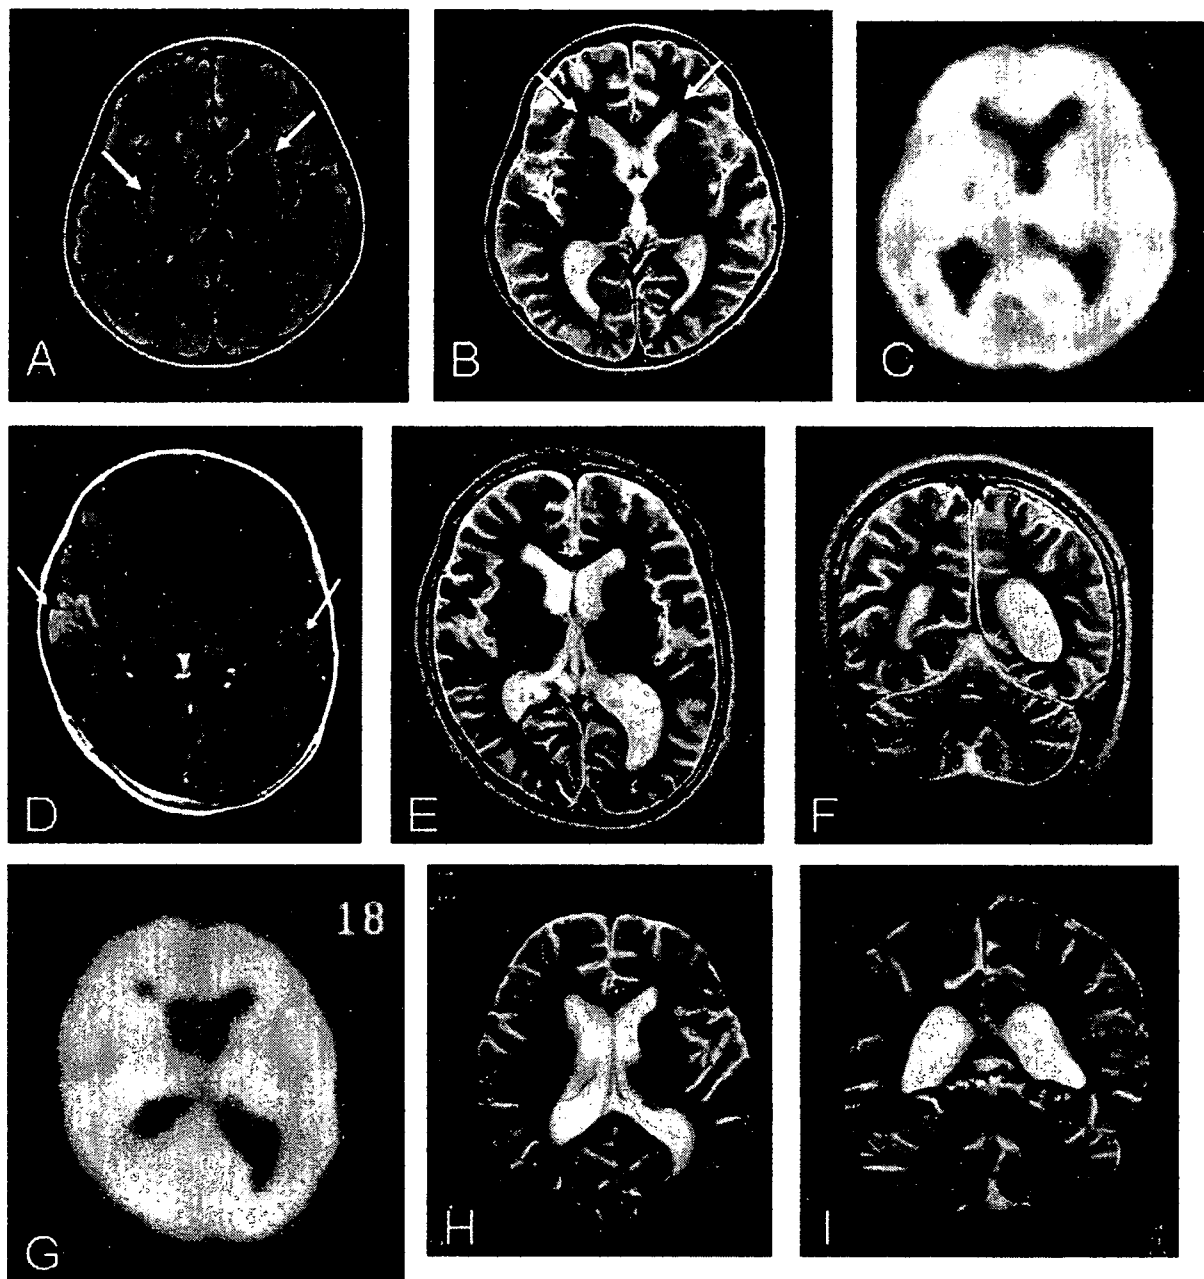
Neuroradiological findings of patients with AERRPS (A–C, patient 1; D–G, patient 2; H and I, patient 3). (A) Fluid-attenuation inversion recovery (FLAIR) image showed high signal intensity in bilateral caudate (arrows). (B) Diffuse cortical atrophy appeared during the recovery phase, in association with a high-intensity lesion at the periventricular white matter (arrows) on T2-weighted MR image (T2WI). (C) SPECT study revealed a slight decrease of blood flow at the bilateral frontal cortex. (D) Enhancement of bilateral temporal cortex is observed. (E and F) Diffuse, mild cortical atrophy can be seen in the cerebrum (E) and cerebellum (F) on T2WI. (G) Widespread decreased perfusion with left-sided predominance is seen in the cerebral cortex and basal ganglia. (H and I) T2WI. Diffuse, mild atrophy of cerebral and cerebellar cortex is seen.
